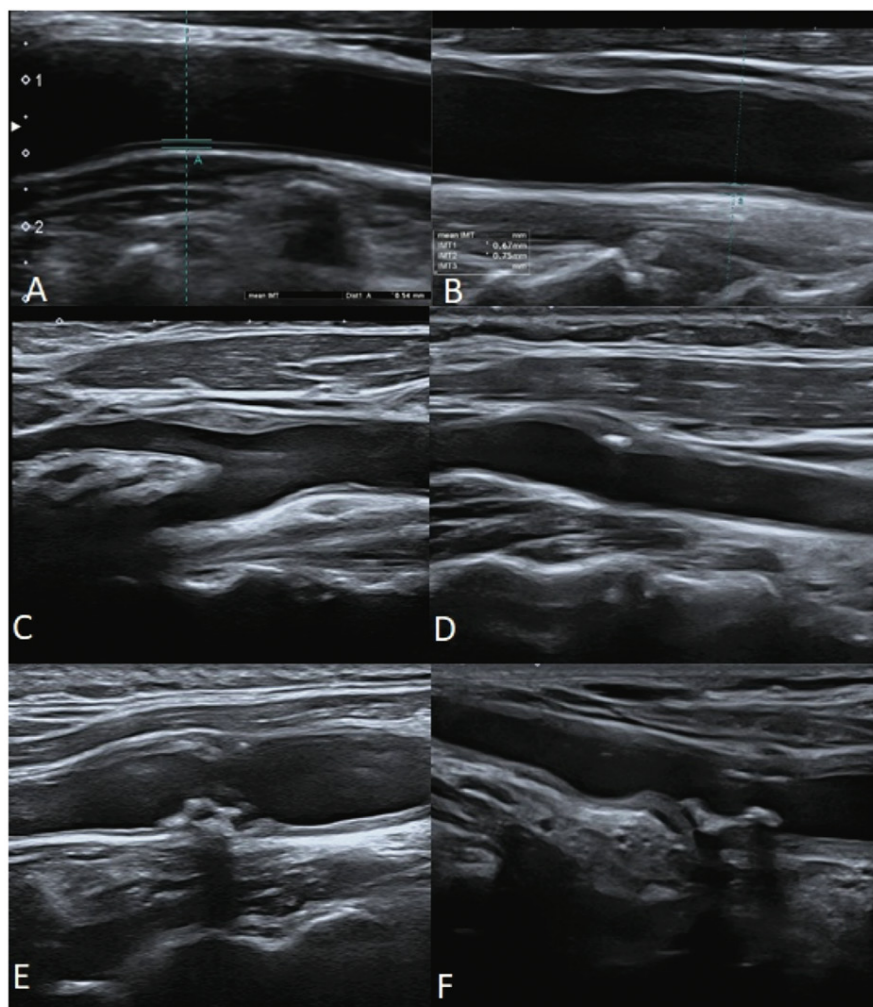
CCA IMT measurement and B-mode US view of various carotid plaques in patients with T2DM (A, B, C and D) and in a patient with TAK (E and F). Measurement of CCA IMT in B-Mode longitudinal image: The two parallel lines are the lumen-intima and media-adventitia interfaces in normal common carotid artery (A) and IMT measurement with thickened wall in CCA (B). A hypoechoic fibrofatty plaque with regular surface in posterior wall (C) and anterior wall of CCA (D). A heterogeneous plaque with a focus of calcification (E) and a calcified plaque with shadowing (F). TAK: Takayasu's arteritis; T2DM: type 2 diabetes mellitus; US: ultrasonography; CCA IMT: carotid artery intima media thickness.
